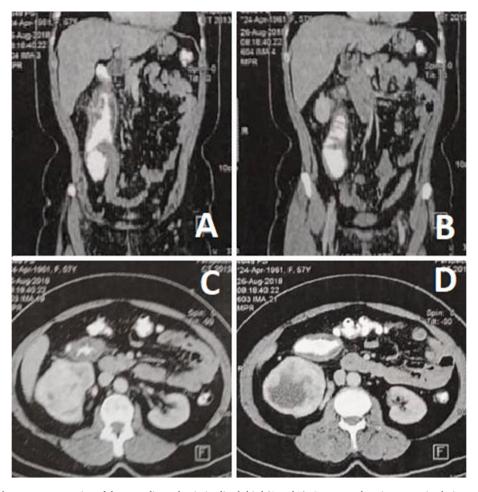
Abdominal CT with apparent narrowing of the ascending colon in its distal third (A and B). Contrast-enhancing expansive lesion, measuring 7x6x7 cm in the lower pole of the right kidney, with a central hypodense area, not capturing contrast (C and D).
